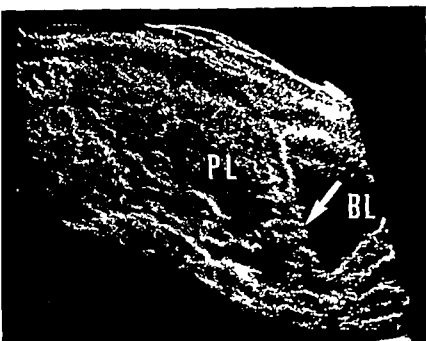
Longitudinal ultrasonic B scan at the 27th week of pregnancy. Total placenta previa (PL) on the anterior wall of the uterus. BL=urinary bladder. arrow indicates the area of internal os of cervix.
